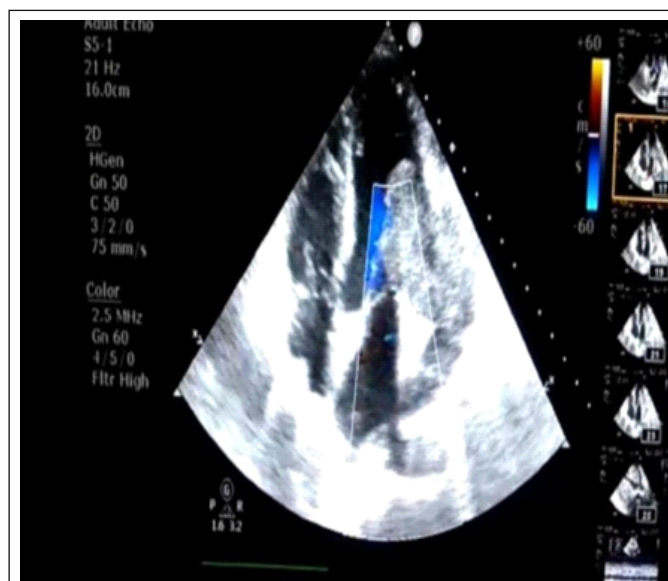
Echocardiography showing Left Ventricle mass seen present size 4.0cm*2.0cm
